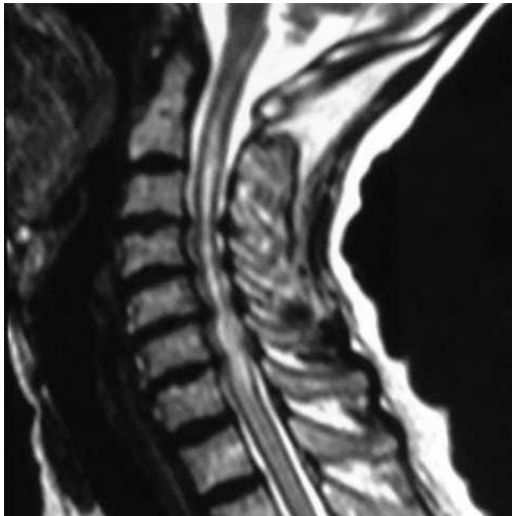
Preoperative sagittal T2 MRI showing cord edema at the level of C3,4 (arrow head) and starting syrinx at the level of C6 (arrow) supporting the theory of (pre-syrinx) (Left). Post operative MRI (T2 sagittal) showing complete resolution of the cord edema and the starting syrinx.
